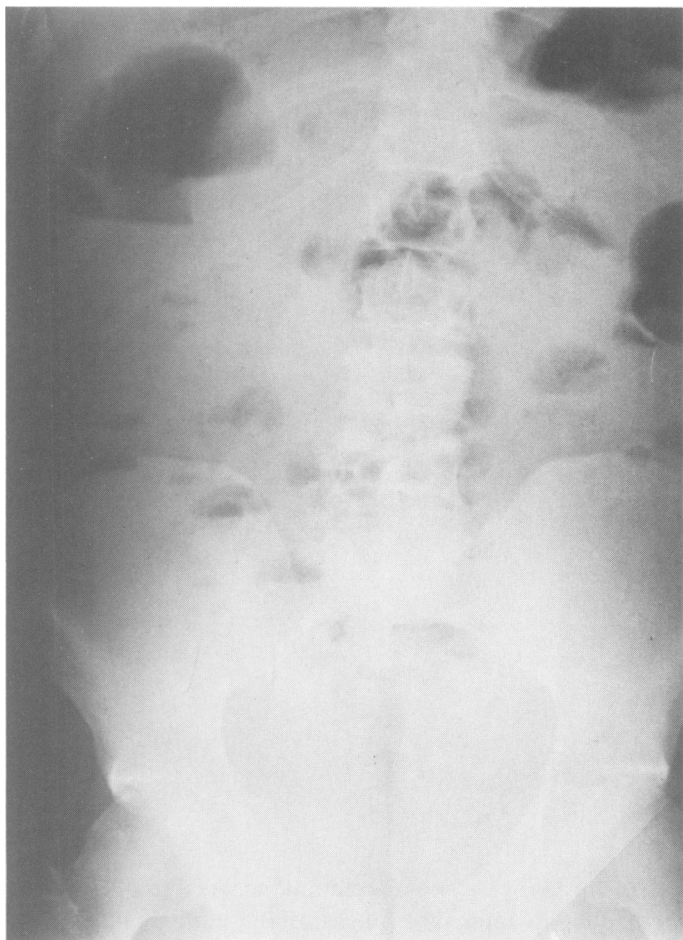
(H.P.) Upright roentgenogram of the abdomen taken on admission to hospital and showing multiple air-fluid levels.
